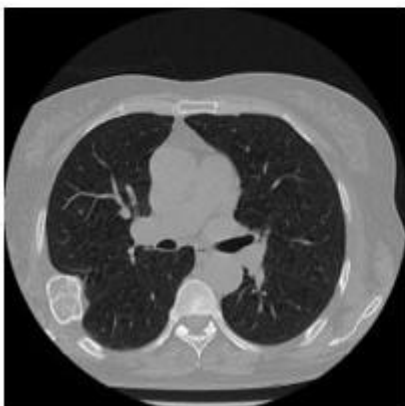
Axial CT scan demonstrating lesion arising from 5th rib (lung window)
